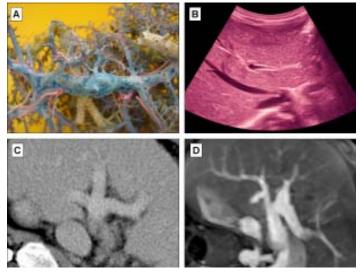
The methods of investigation of the divergence part of hepatic portal vein. A - The piece of corrosion cast; B - ultrasound image; C - MDCT angiography images; D - MR - angiography images.
